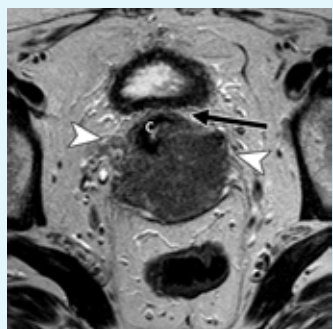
Axial T2-w MRI scan in a 54-year-old woman showing a large tumor of intermediate signal (arrowheads) originating from the posterior aspect of the cervix (C) extending into the parametrium; the posterior upper vaginal wall was also involved. The fat plane between the cervix and posterior bladder wall (arrow) is maintained. This is consistent with a stage IIB tumour.
